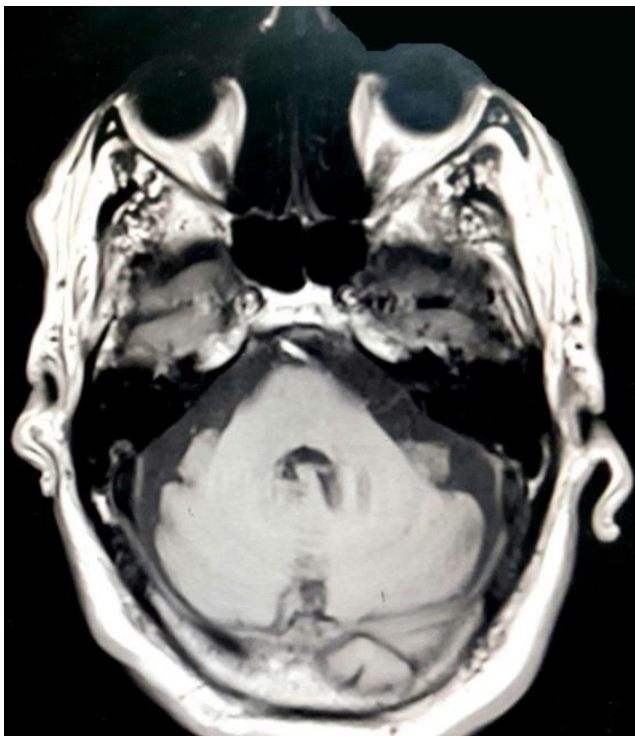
MRI T1 scan (in 2020) for the brain which shows the cross of the basilar artery from the left side to the right side.
